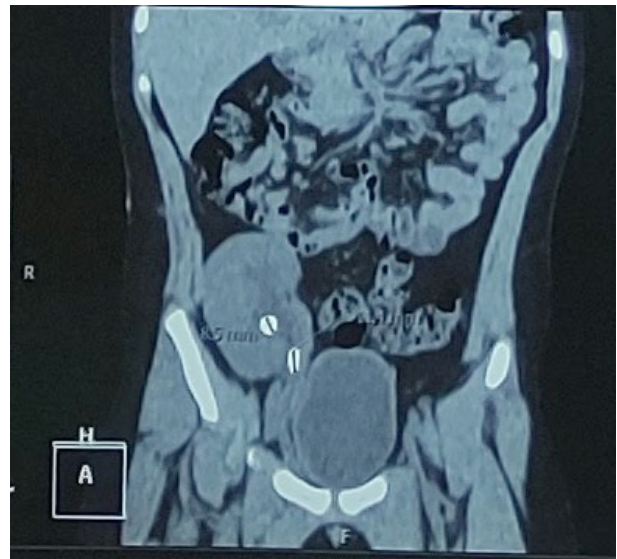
Pretreatment CT scanner: The coronal computed tomographic
